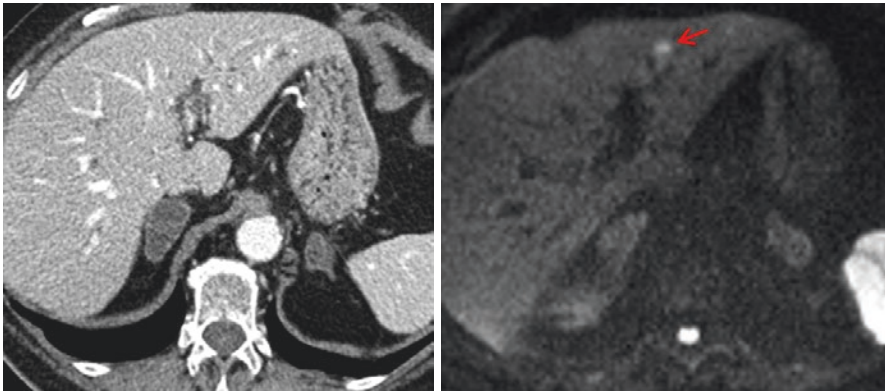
Male, 77 year old with pancreatic carcinoma and subtle liver metastases. Axial liver MDCT scan (left) and MRI–DWI (right) at time of diagnosis. No liver lesions were detected in CT scan, but in the MRI scan (DWI) there was a small liver metastasis in the left liver lobe (arrow)
